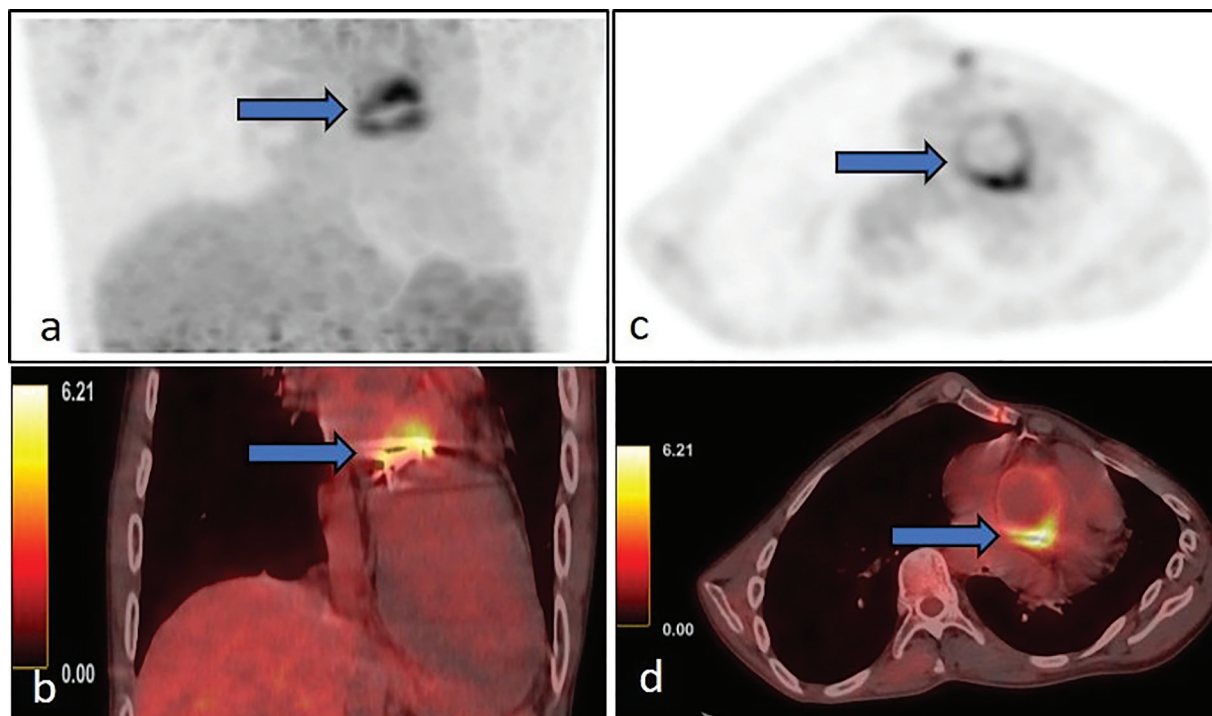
A 28 years-old-male patient with Marfan syndrome associated with severe aortic regurgitation and dilated aorta underwent aortic valve replacement surgery. One month later, he developed fungal prosthetic valve endocarditis with positive blood culture (*Candida albicans* and *Candida parapsilosis*), and 2D transthoracic echocardiography (TTE) showed multiple vegetations on the anterior mitral leaflet and the prosthetic aortic valve. After 6 weeks of treatment, repeat blood culture, 2D TTE and transesophageal echocardiography were negative for residual active disease. ¹⁸F-fluorodeoxyglucose positron emission tomography/computed tomography (¹⁸F-FDG PET/CT) (a-d) was performed to confirm any residual active focus in the heart before proceeding towards step-down approach to therapy. Cardiac non-attenuation corrected (NAC) maximum intensity projection and axial images (a,c) and corresponding fused PET/CT coronal and axial images (b,d) showed circumferential heterogeneously increased metabolic activity along the aortic prosthetic valve, suggestive of persistent residual infection. Increased metabolic activity on the NAC image ruled out a false-positive result due to overcorrection by the metallic prosthesis. Positive ¹⁸F-FDG-PET/CT led to continuation of antifungal treatment in this case. Fungal endocarditis accounts for 1% to 3% of all infective endocarditis (IE) cases, affects nearly 0.1% of all prosthetic cardiac valves, and is disproportionately associated with a high morbidity and case fatality rate (>70%); it also presents greater diagnostic challenges compared with bacterial IE (1). *Candida* species are the most common cause of fungal endocarditis (2). Blood cultures and echocardiography can be falsely negative, as in this case. ¹⁸F-FDG-PET/CT has high sensitivity and specificity of 86% and 84%, respectively for IE (3). 2023 Duke-International Society for Cardiovascular Infectious Diseases Criteria for Infective Endocarditis Criteria has incorporated ¹⁸F-FDG-PET/CT in the major imaging criteria for its diagnosis owing to its high positive predictive value (4).
